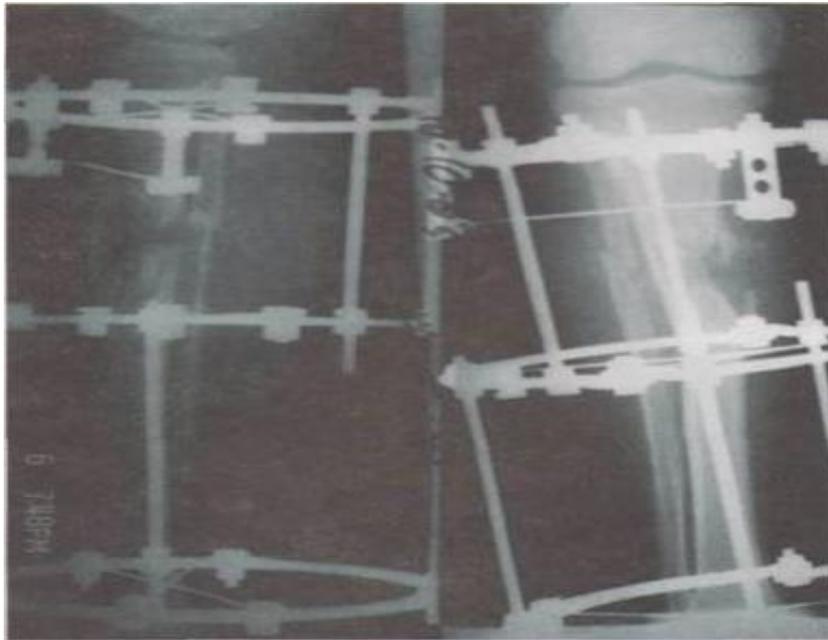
Postoperative radiograph of patient S. The condition after extra-focal osteosynthesis using the Ilizarov apparatus.
